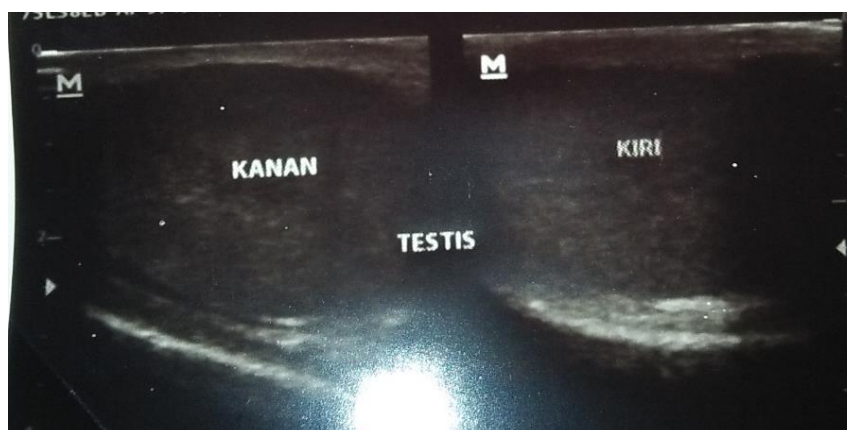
Gray scale ultrasound without Doppler showed on the left: right testicle with heterogenous echogenicity, on the right: left testicle with normal echogenicity
